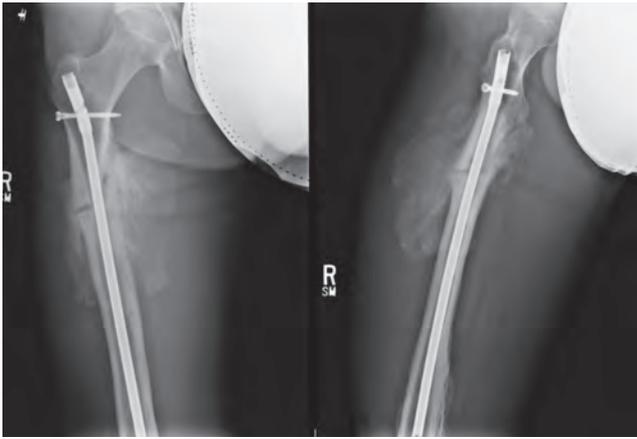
Final follow-up radiographs of right femur fracture at 6 months postoperatively showing bridging callus formation and heterotopic ossification.
